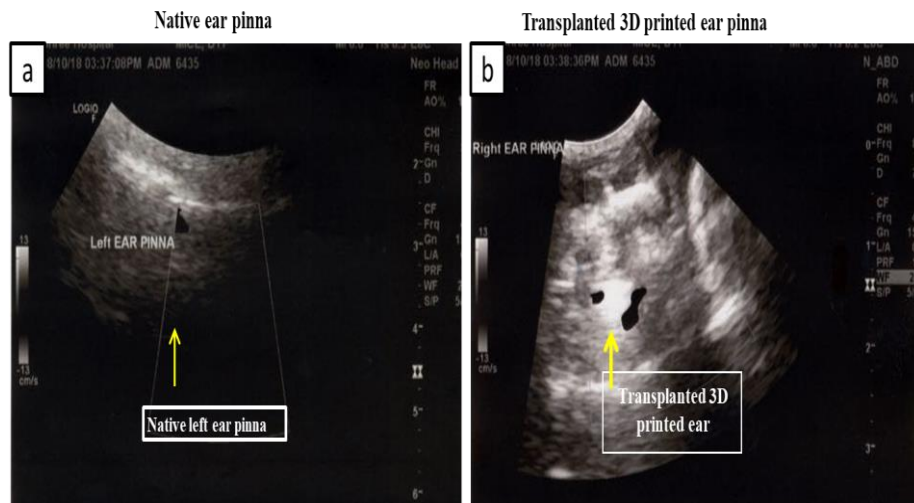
Ultrasound sonography (USG) of transplanted 3D printed ear pinna
